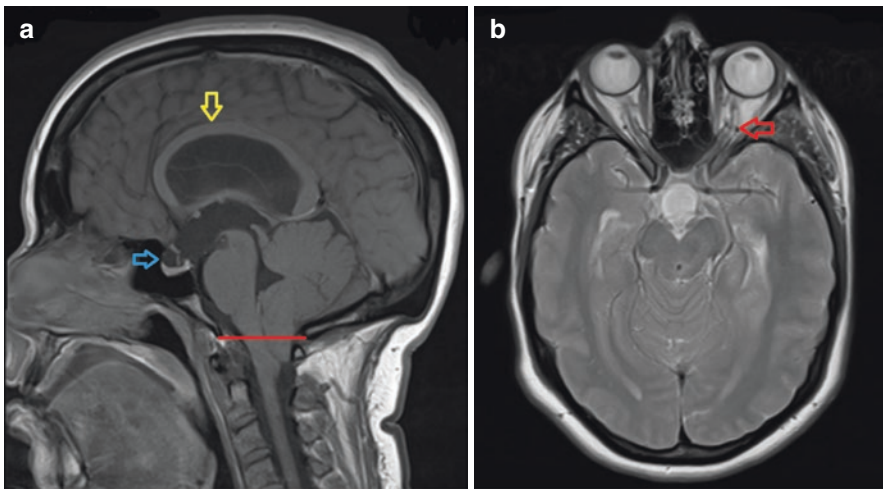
A MRI scan of a 33-year-old patient with headache and blurred vision due to mild papilloedema. (a) Sagittal T1 sequence shows arching of the corpus callosum (yellow arrow) due to hydrocephalus, partially empty sella (blue arrow), and tonsils 12 mm below the foramen magnum (red line). (b) Axial T2 sequence shows dilated optic nerve sheaths with redundant retrobulbar segment. The appearances are suggestive of chronically raised intracranial pressure
